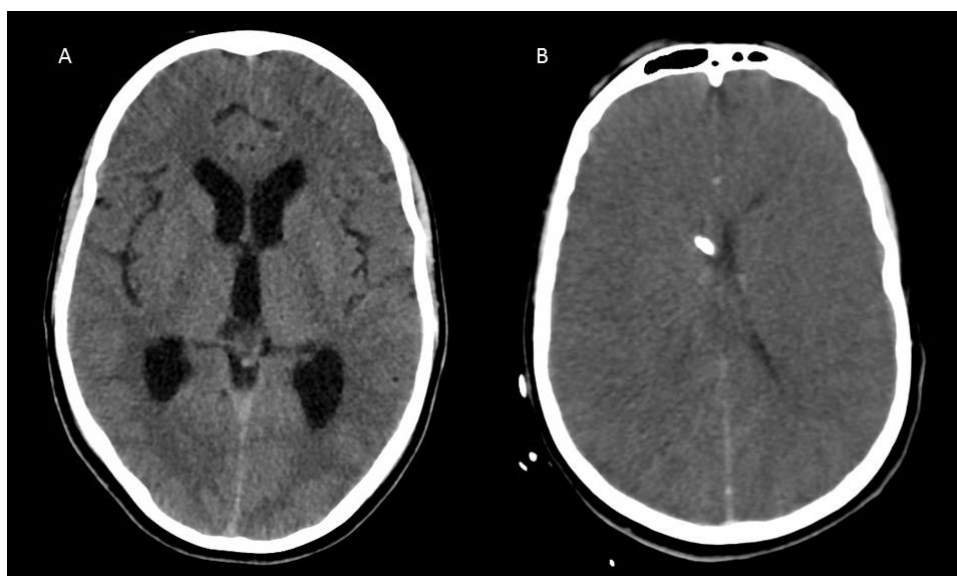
Axial CT images of brain showing communicating hydrocephalus (A) and slit like ventricles following insertion of an external ventricular drain (EVD) (B).
